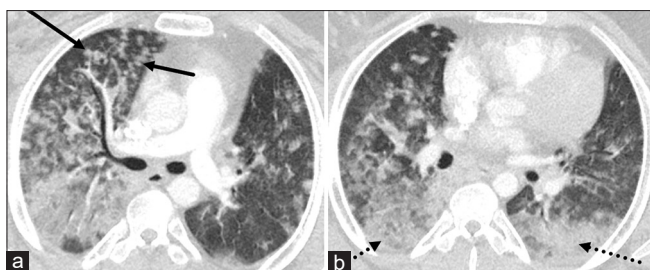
Axial chest computed tomography images (a and b) of a 17-year-old male with a history of vaping show a pattern consistent with diffuse alveolar damage with patchy nodular opacities in a centrilobular distribution (black arrows) and basilar consolidation (dashed black arrows)
